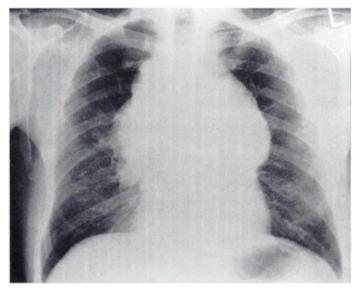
Chest radiograph at time of admission showing large mediastinal mass.
